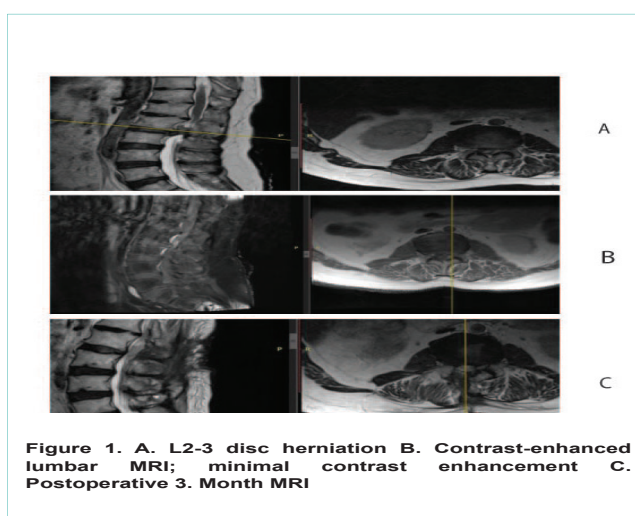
A. L2-3 disc herniation B. Contrast-enhanced lumbar MRI; minimal contrast enhancement C. Postoperative 3. Month MRI
